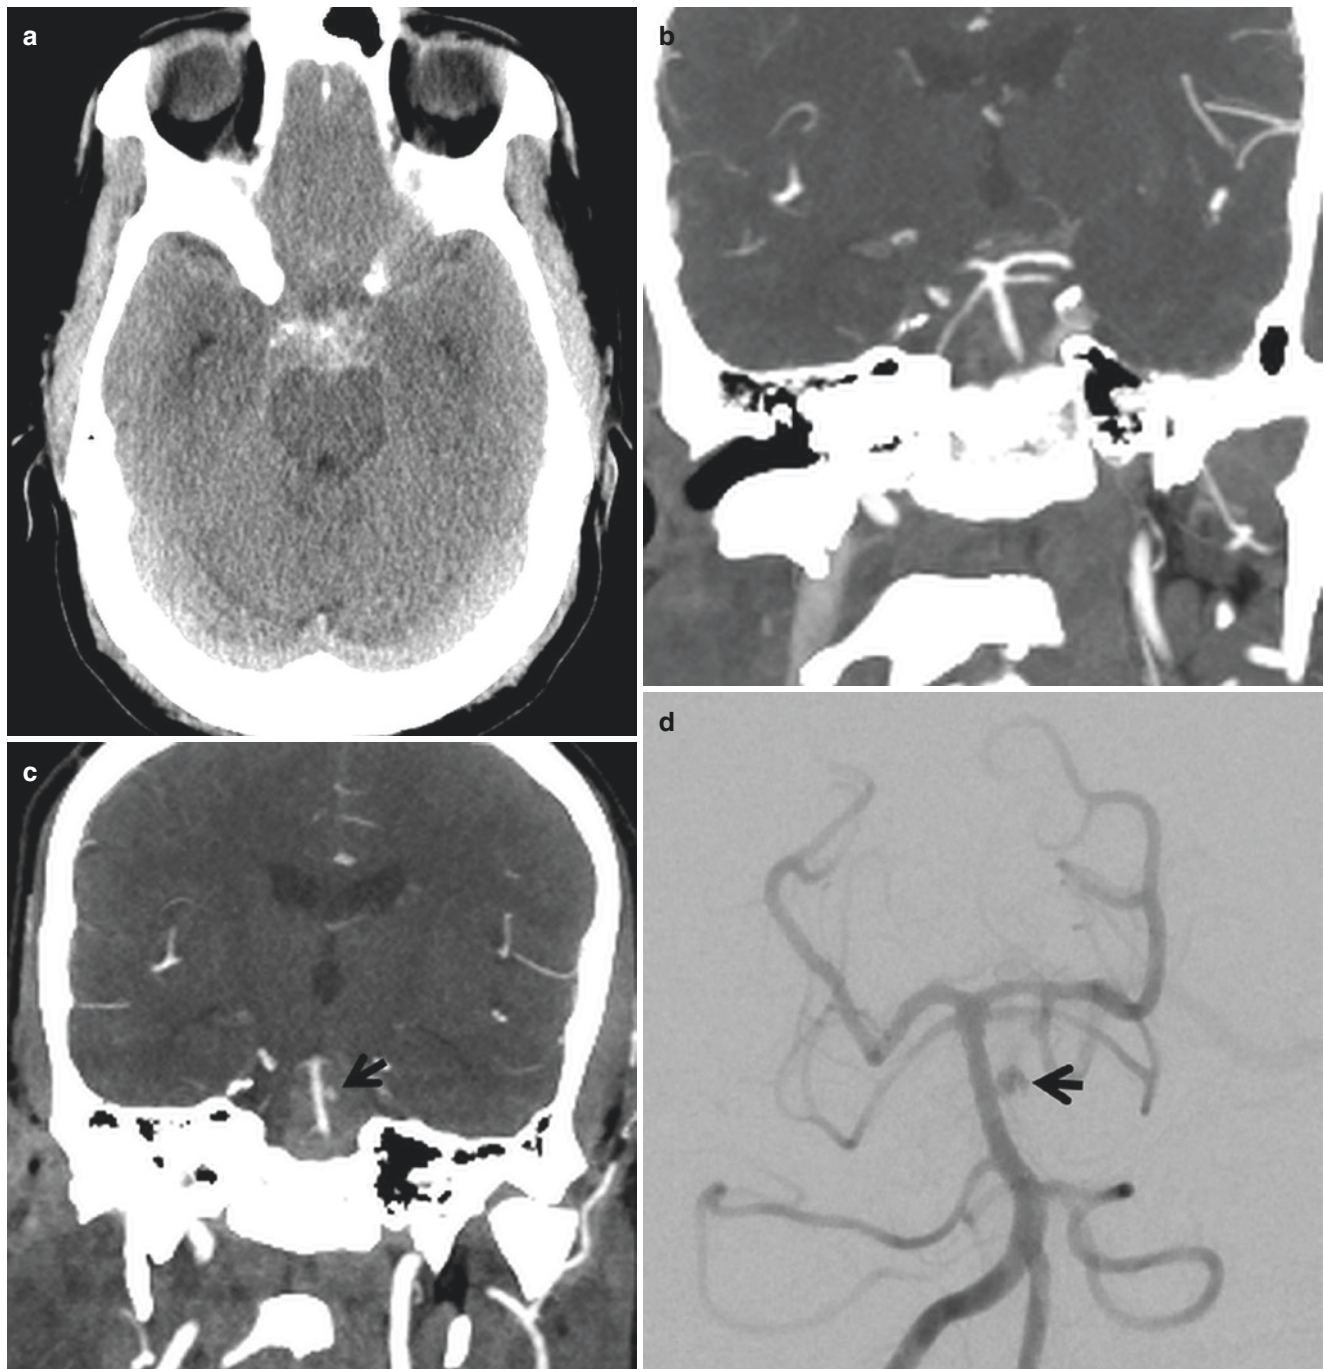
Occult aneurysm. (a) NCCT shows a perimesencephalic SAH pattern. (b) Initial CTA is negative for aneurysm. DSA is also negative (not shown). (c) Follow-up CTA coronal image shows a blister
